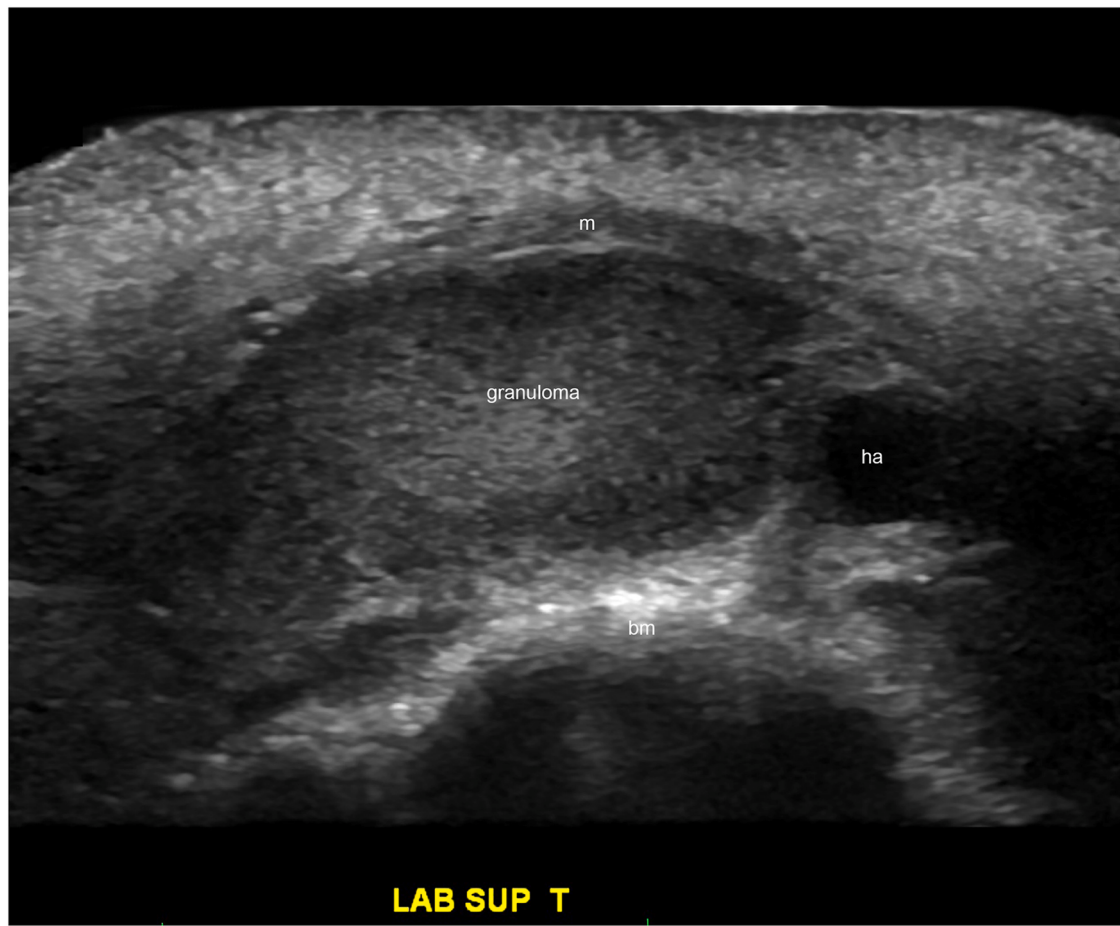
Ultrasound (transverse view; grayscale) of the lesion shown in [Figure 5](#) demonstrates a submucosal and oval-shaped, hypoechoic nodule that corresponds to a granuloma and a small hyaluronic acid deposit in the periphery. Abbreviations: ha, hyaluronic acid; m, orbicularis oris muscle.
